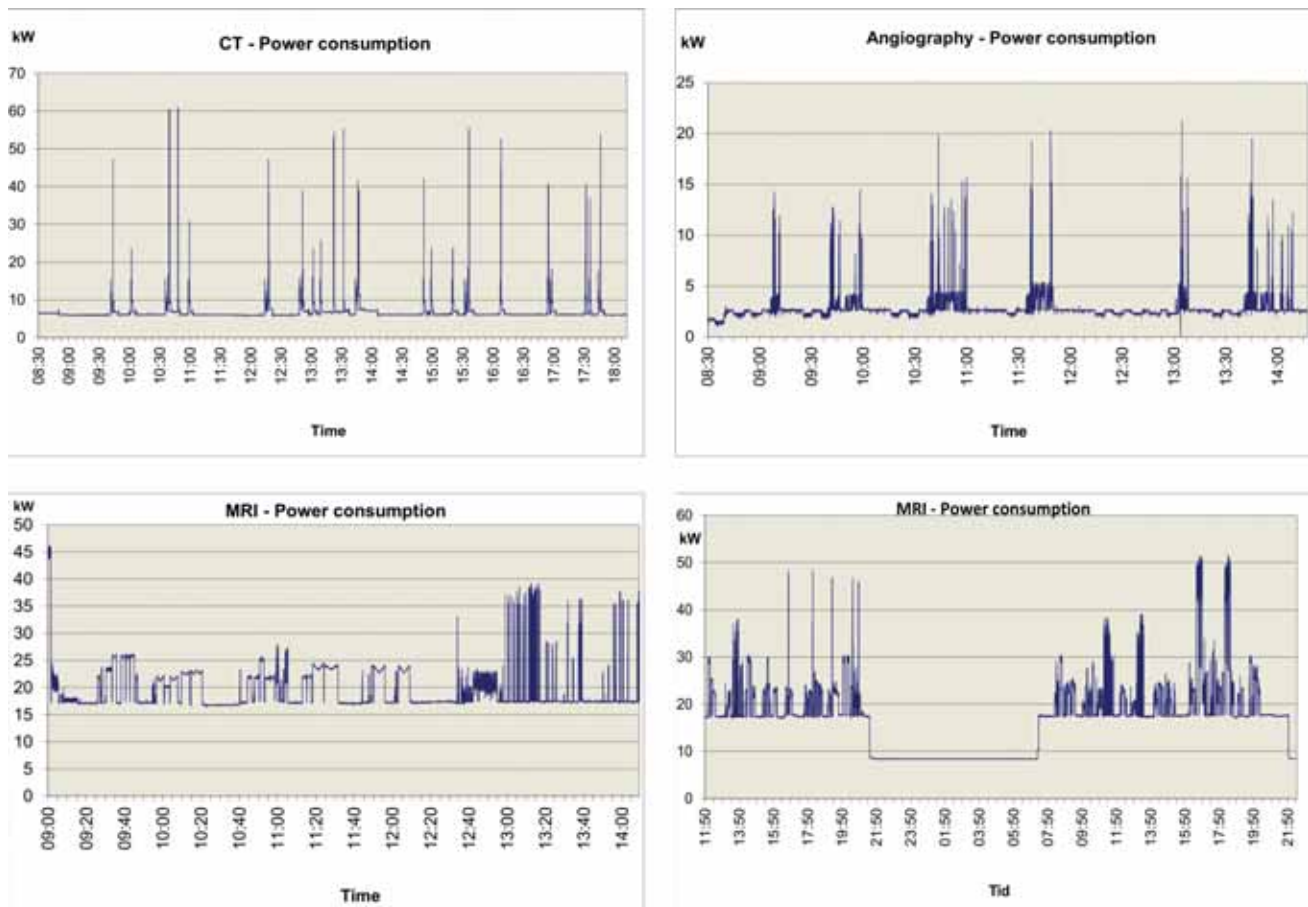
a-d: Presentation of electrical power as a function of time for - a) CT Scan, b) Angiography, c) MRI plot during daytime, d) MRI plot during 24 hours
